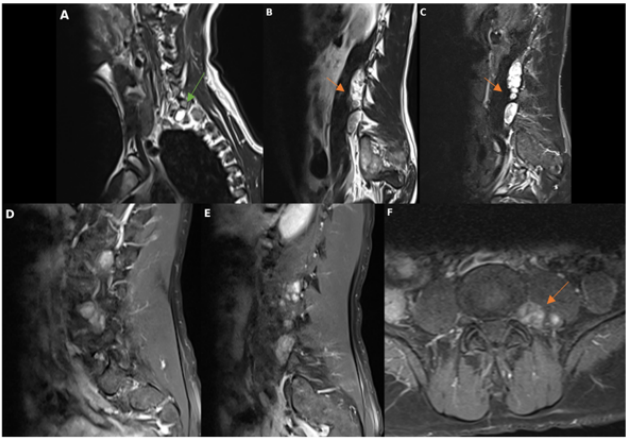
Spinal MRI. (A) Sagittal image at the cervical level showing straightening of the cervical spine with staged marginal osteophytosis (Green arrow), (B) Sagittal T1-weighted image at the lumbar level showing multiple small left-sided paraspinal masses, isointense to muscle, with a thin peripheral rim of fat outlining the lesions (split-fat sign) (Orange arrow), (C) Sagittal T2-weighted image at the lumbar level showing the same lesions in marked hyperintensity (Orange arrow). (D) Sagittal fat-suppressed post-gadolinium T1-weighted image showing intense enhancement of the left-sided paraspinal lesions. (E) Sagittal fat-suppressed post-gadolinium T1-weighted image at a more caudal level showing multiple additional small enhancing lesions at staged levels. (F) Axial fat-suppressed post-gadolinium T1-weighted image showing a left-sided paraspinal enhancing lesion, with the split-fat sign visible at its margin, supporting its neurogenic origin (Orange arrow).
